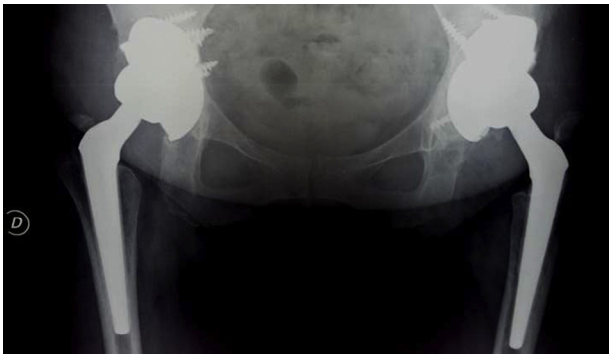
Annual follow-up X-ray showing the correct positioning of the implants with restoration of the rotation centers.
